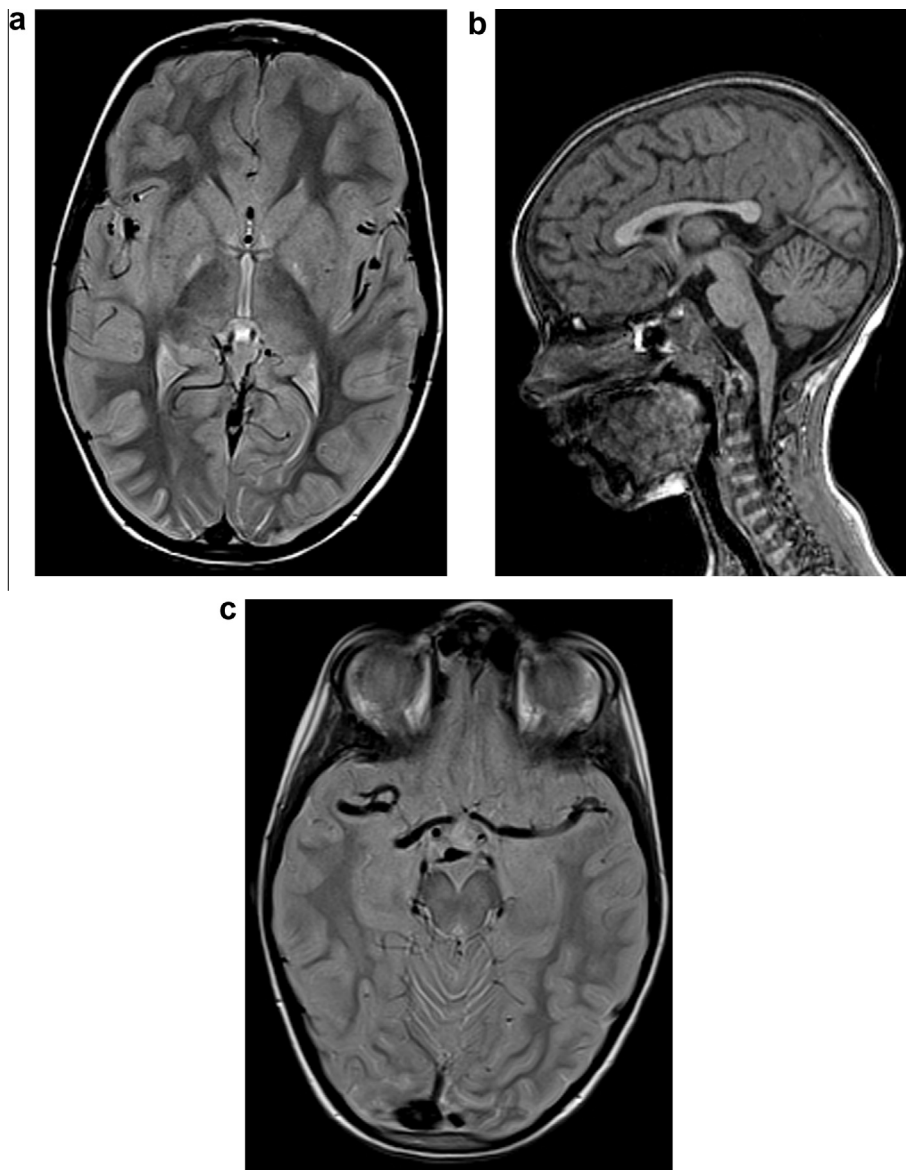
(a) Axial PD-weighted image shows bilateral hyperintense signal of globus pallidi. (b) Sagittal T1-weighted image, showing a thin corpus callosum. (c) Axial PD-weighted image shows a mild and homogeneous ectasia of both distal internal carotid arteries and middle cerebral arteries.
